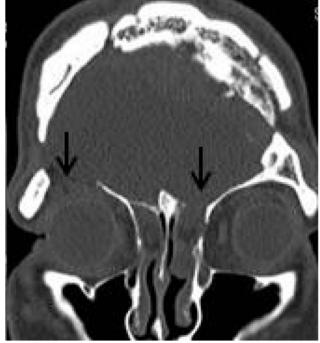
(a) Plain computed tomography scan of the sinuses and brain (coronal cut) showing a defect of the roof of the right ethmoid with a soft tissue opacification in the ethmoid sinus suggesting the presence of a meningocele. (b) Multiple defects involving the left roof of ethmoid and cribriform plate (arrow) and roof of right orbit (arrow).
